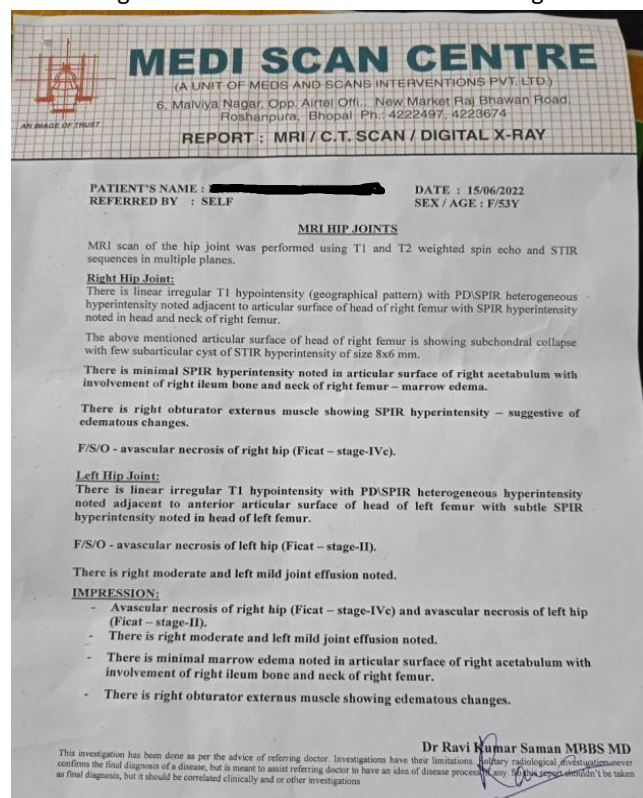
MRI report of a patient
